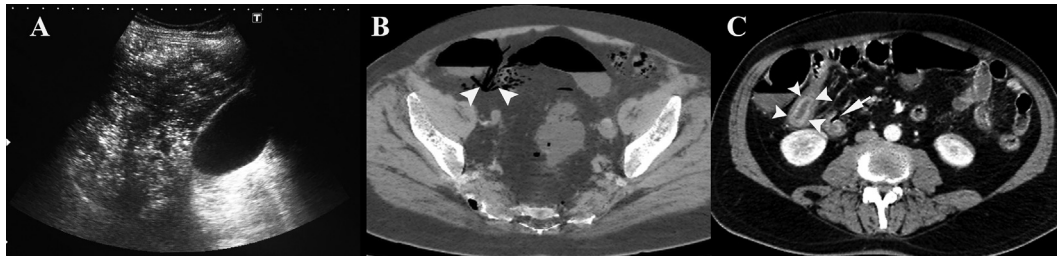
Ultrasound of the liver demonstrates widespread millimeter-sized hyperechoic particles consistent with air bubbles (A). Abdominal CT images show air bubbles within the mesenteric veins (arrowheads) (B), pneumatosis intestinalis (arrowheads) and air bubbles in the thickened intestinal wall (arrow) (C).
